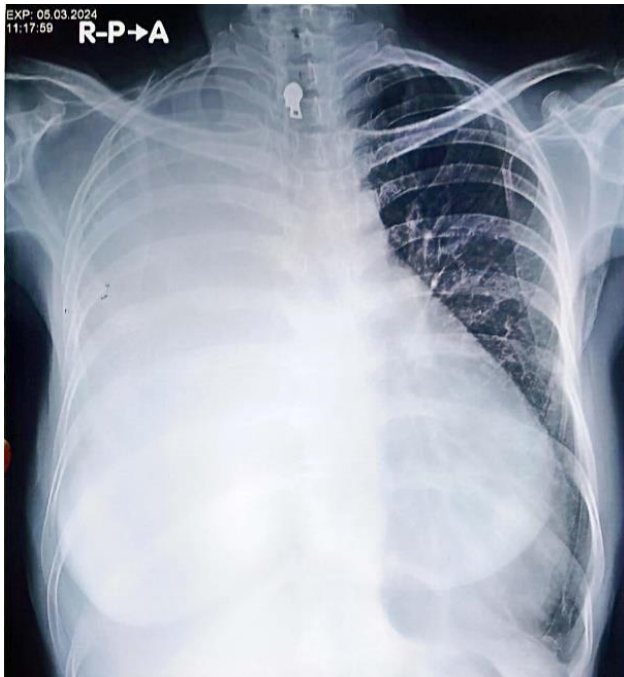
Chest X-Ray of the PA position showed right pleural effusion.
